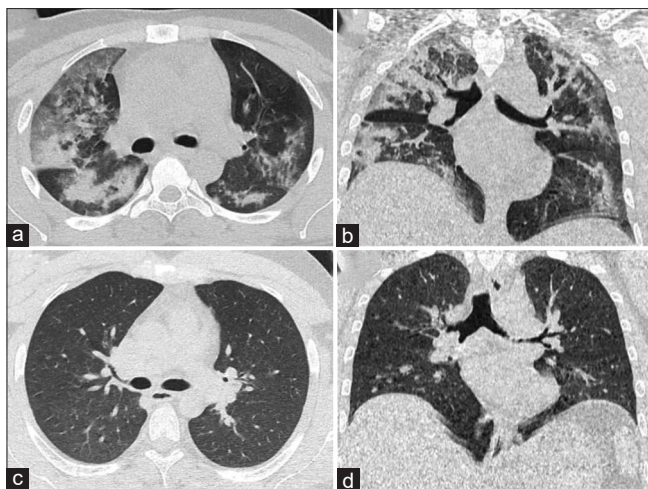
High-resolution computed tomography axial (a) and coronal (b) scans of an unvaccinated 32-year-old male coronavirus disease-2019 patient showed ground-glass opacities and consolidation in bilateral lung fields with computed tomography severity score 17/25. Axial (c) and coronal (d) another coronavirus disease-2019 patient of the same age and sex admitted in the same time frame but with two doses of vaccination showed almost clear lung fields
